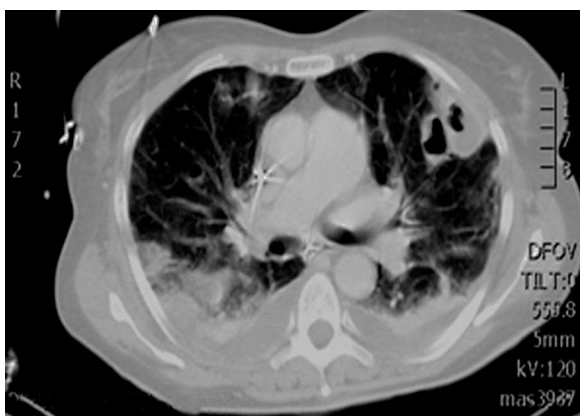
High resolution computed tomography of the thorax showing cavitation of previous lesions.
